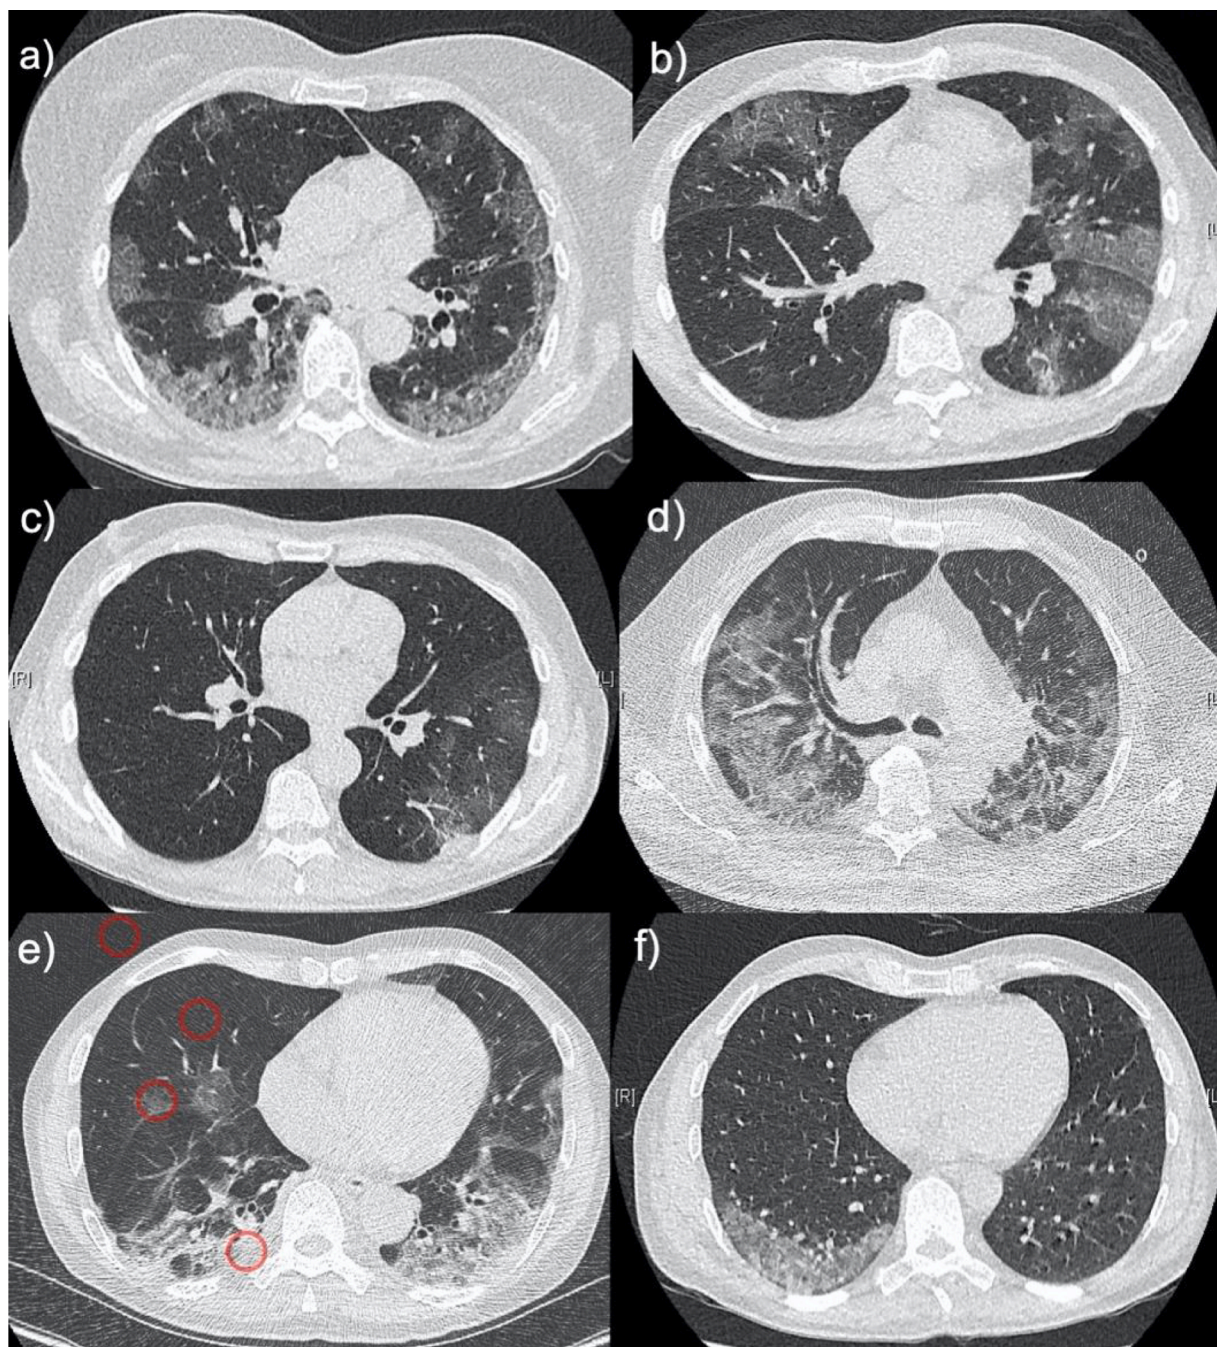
Example cases of six patients with typical findings of COVID-19 in low-dose-chest CT.
